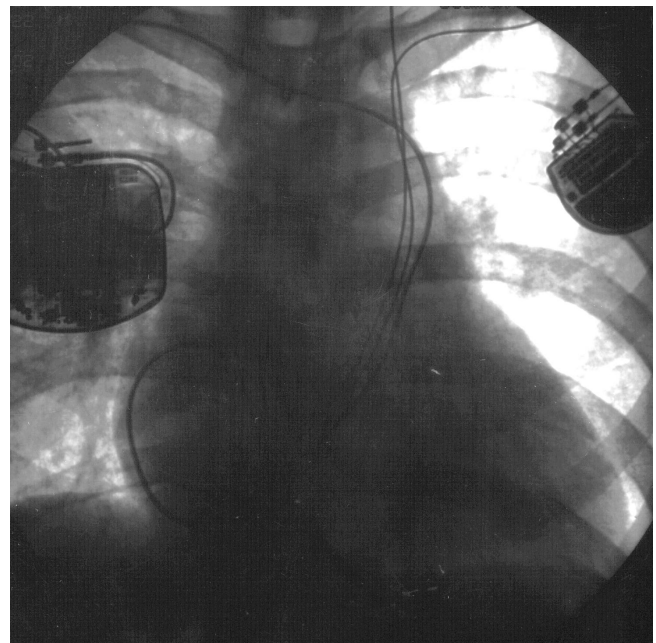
Thoracic x-ray showing the location of the implanted cardioverter-defibrillator, the pacemaker and all leads.
